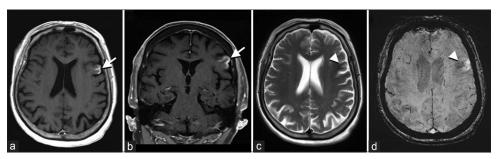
Brain magnetic resonance imaging revealed focal cortical and leptomeningeal enhancement over the left inferior and middle frontal gyri (Brodmann area 44, arrows) on contrast-enhanced T1-weighted image (a: axial, b: coronal) along with abnormal hypointensity at the subcortical white matter (arrowheads) on T2-weighted image (c) and susceptibility-weighted image (d). No abnormal signal was noted at the affected cortices on T2-weighted image
